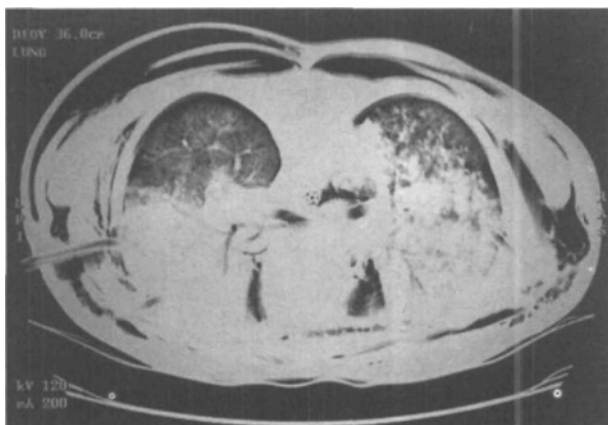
Case report #2: CT of the thorax in prone position demonstrates extensive traumatic injury of both lungs with homogenous lung haemorrhage ventrally as well as pneumothorax and soft tissue emphysema
